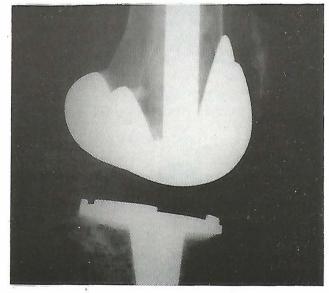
X-rays of knee lateral view after removal of bone cement block and revision total knee arthroplasty.
